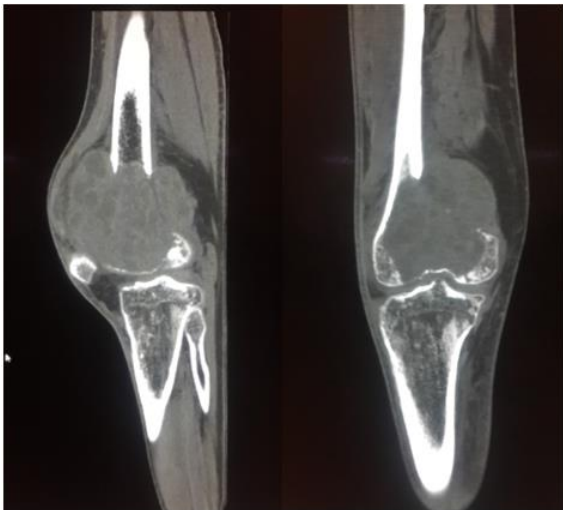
CT-scan revealing the amount of bone destruction.
